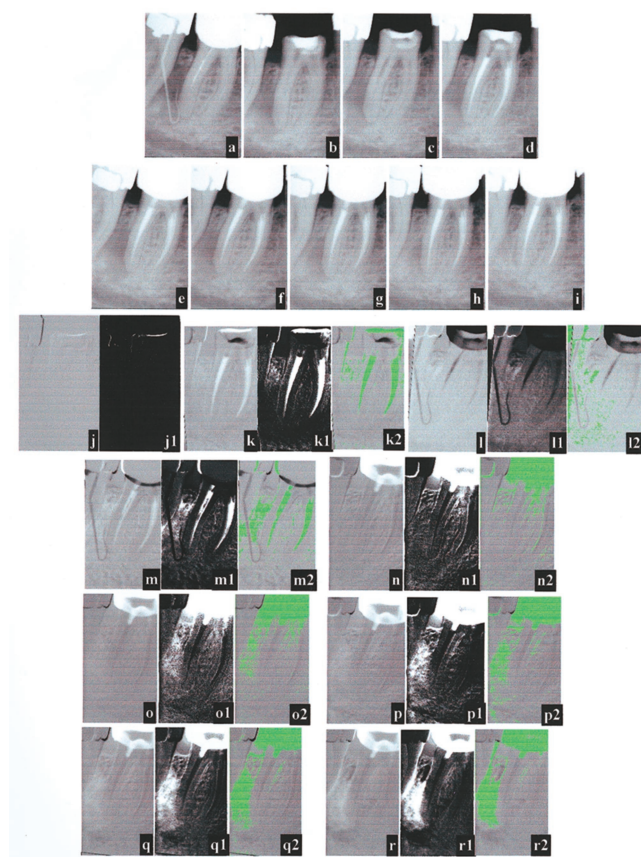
(a) Preoperative radiograph of a first mandibular molar (46). Intraoral fistula is traced with a gutta-percha cone. (b, c) Control radiographs after 0.5 and 1 month, respectively. (d) Postoperative radiograph 1.5 months later. (e, f, g, h, i) Recall radiographs 0.5, 1.5, 3, 6, and 12 months after obturation, respectively. (j) Result of digital subtraction of (b) from itself. (j1) Image (j) processed using contrast enhancement. (k) Result of digital subtraction of (d) from (b). (k1) Image (k) with contrast enhancement. (k2) Pseudocolored image (k). (l) Result of digital subtraction of (c) from (a). (l1) Image (l) processed using contrast enhancement. (l2) Image (l) processed using pseudocoloring. (m) Result of digital subtraction of (f) from (a). (m1) Image (m) with contrast enhancement. (m2) Pseudocolored image (m). (n) Result of digital subtraction of (e) from (d). (n1) Image (n) processed using contrast enhancement. (n2) Pseudocolored image (n). (o) Result of digital subtraction of (f) from (d). (o1) Image (o) with contrast enhancement. (o2) Image (o) processed using pseudocoloring. (p) Result of digital subtraction of (g) from (d). (p1) Image (p) processed using contrast enhancement. (p2) Pseudocolored image (p). (q) Result of digital subtraction of (h) from (d). (q1) Image (q) with contrast enhancement. (q2) Image (q) processed using pseudocoloring. (r) Result of digital subtraction of (i) from (d). (r1) Image (r) processed using contrast enhancement. (r2) Pseudocolored image (r).
